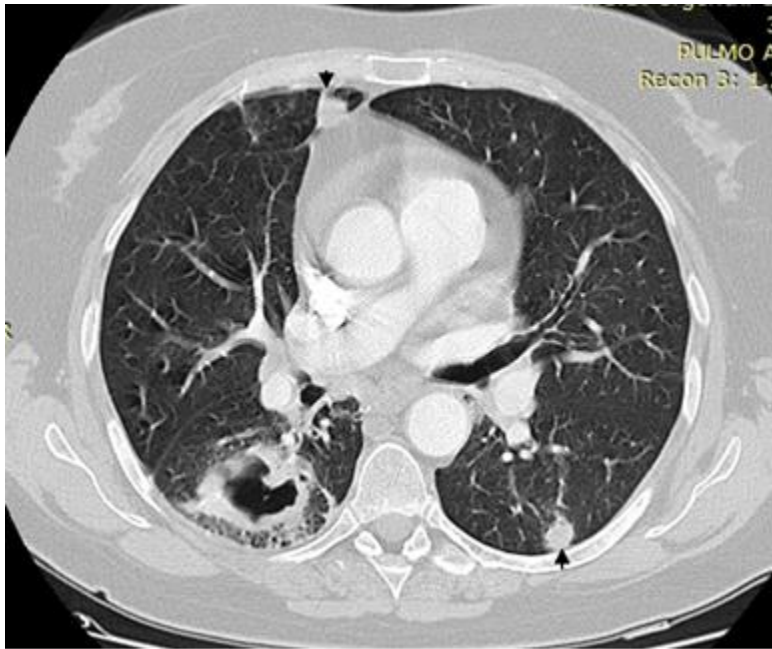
Axial computed tomography view in lung window setting demonstrates a large cavitary mass with thick irregular borders in the right lower lobe, and the nodules in both lungs (arrows) in granulomatosis with polyangitis
